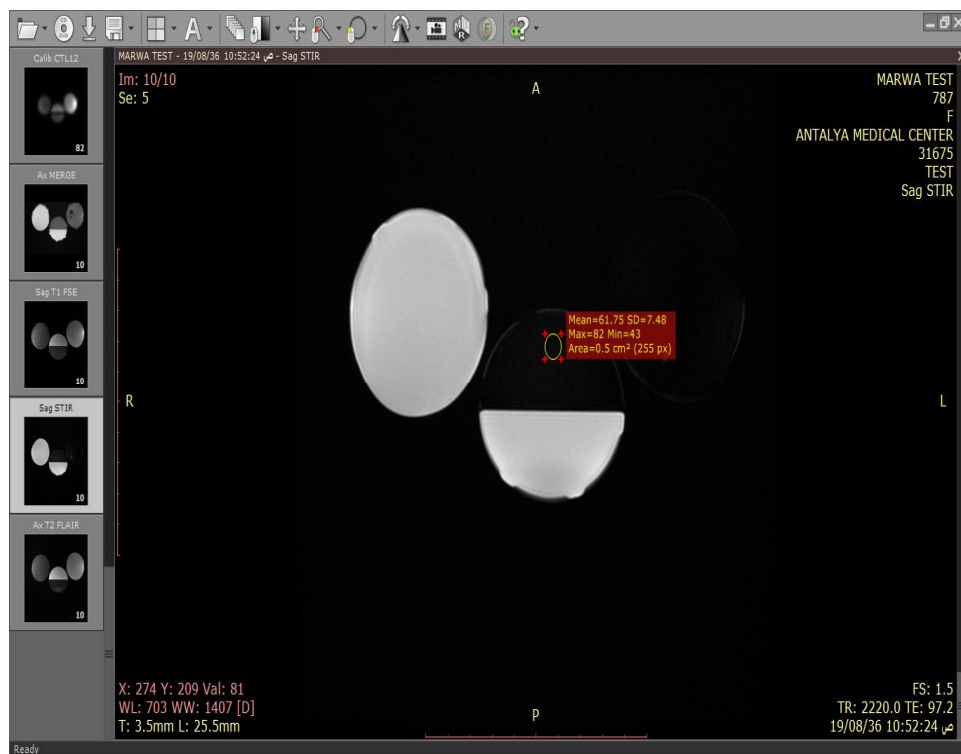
Sag STIR image taken by GE MRI 1.5T in Antalya medical center.
